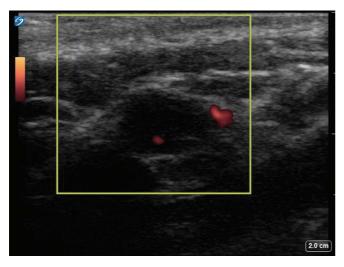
Hyperechoic soft tissue mass on color power Doppler. There is flow detected in the hilum and periphery of this presumed lymph node.
